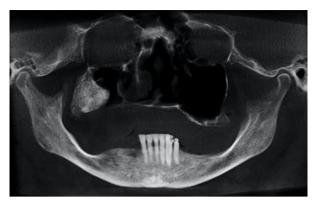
Image exam of the lesion: computed tomography scan panoramic view showing extensive hyperdense lesion with hypodense areas.
